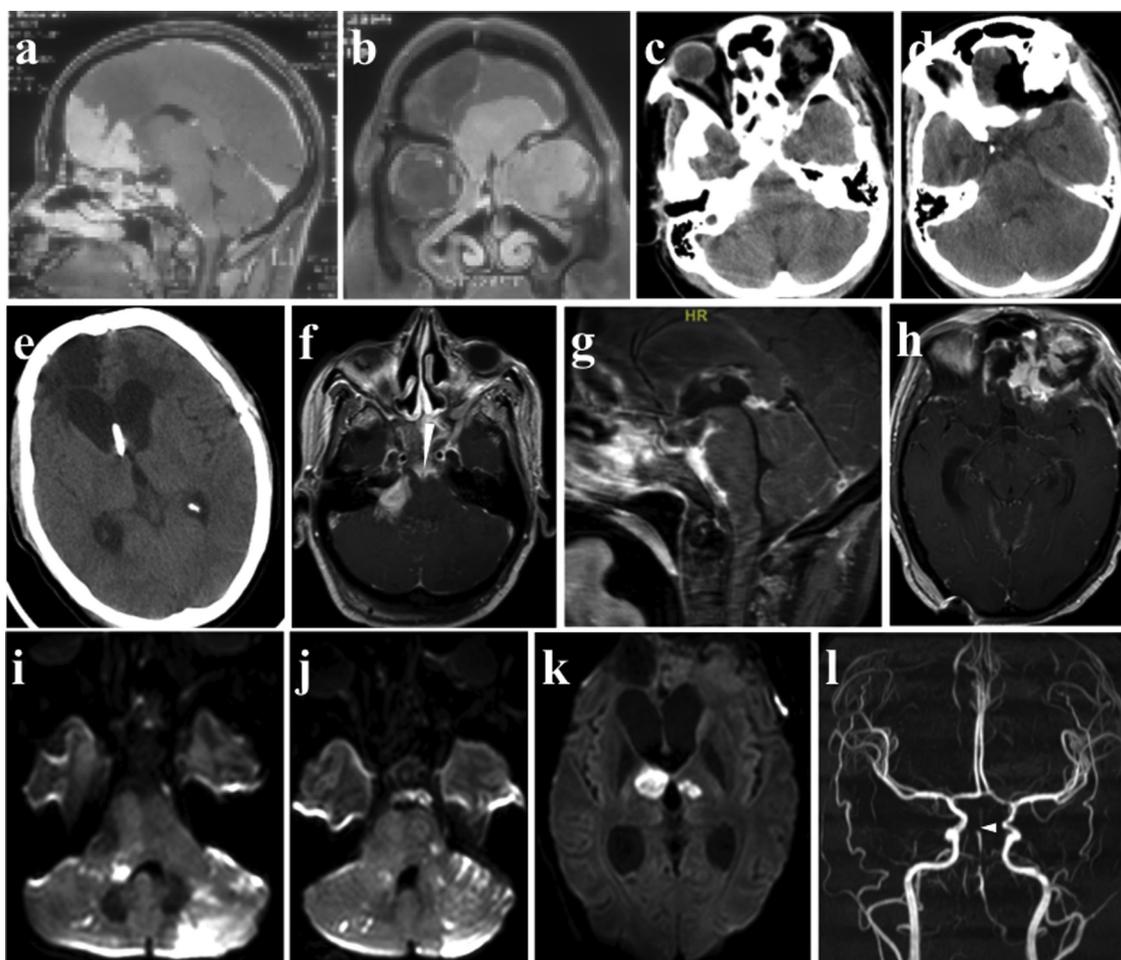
A 33-year-old female patient (no:18 in Table 4) presented with proptosis, headache and vomiting. MRI revealed homogeneously enhancing lesion involving left basifrontal region, left orbit and paranasal sinuses (a&b). There was another lesion in preontine region and right cerebellopontine angle (CPA) (a). Patient underwent gross total excision of basifrontal lesion (c&d) and also underwent ventriculoperitoneal shunt placement for hydrocephalus (e). However, two months after surgery, while on anti fungal treatment she deteriorated. MRI at this time showed persistent lesions in CPA and preontine region (f–h) completely encasing and obliterating the basilar artery (white arrow head in f). Diffusion sequence revealed multiple infarcts involving bilateral cerebellar hemispheres, brainstem and thalami (i–k). MR angiography revealed basilar artery thrombosis (white arrow head in l).
